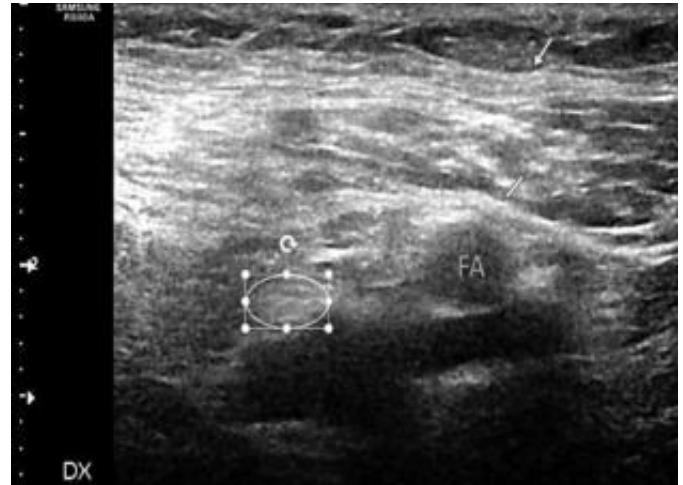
Ultrasound scan performed on the axial plane in the right inguinal region: in the yellow circle is visible the femoral nerve, the yellow arrow indicates the fasciae latae, the green arrow points to the iliac band and, AF indicates the femoral artery.
